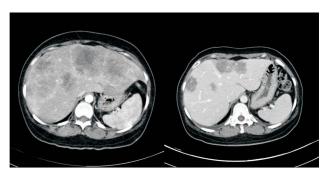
Before (left) and after (right) cetuximab-based infusional 5-FU regimens treatment CT image of liver metastasis.
